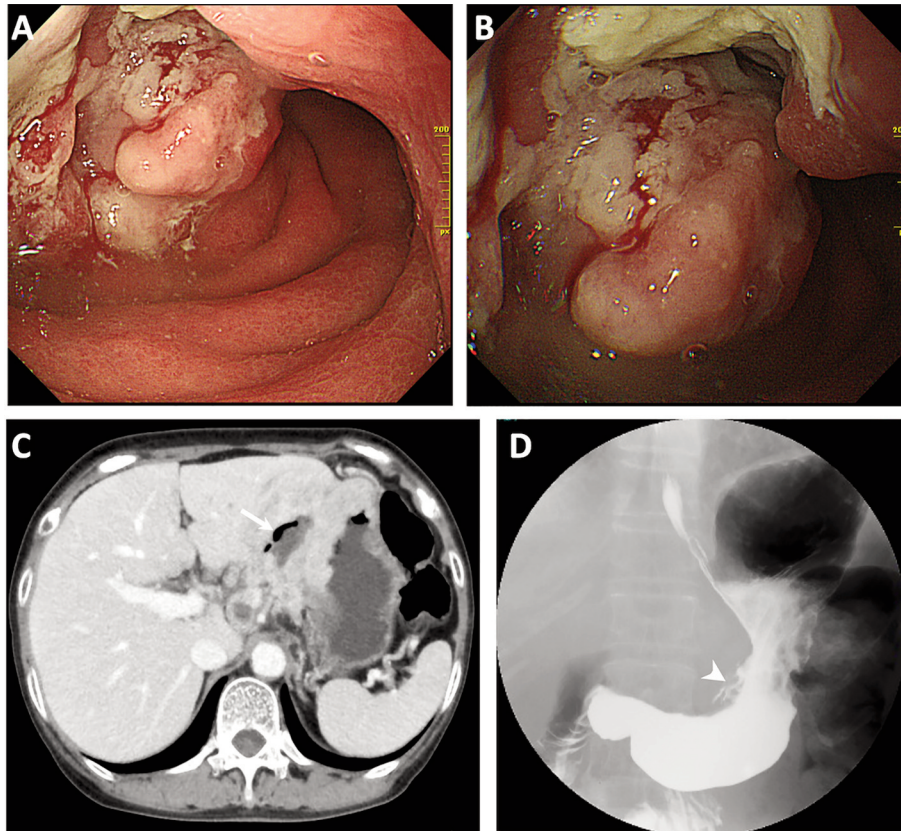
Initial esophagogastroduodenoscopy, computed tomography, and double-contrast upper gastrointestinal imaging. Esophagogastroduodenoscopy revealed an obviously elevated lesion with a central depression in the middle third of the stomach (A and B). Abdominal contrast-enhanced computed tomography showed thickening of the gastric wall and fluid retention with air density in the perigastric area under the lateral segment of the liver (C, arrow). Fluoroscopy of the upper gastrointestinal tract showed a deformity of the gastric contour, poor extension of the gastric wall, and leakage of contrast agent into the perigastric area on the lesser curvature side (D, arrowhead).
